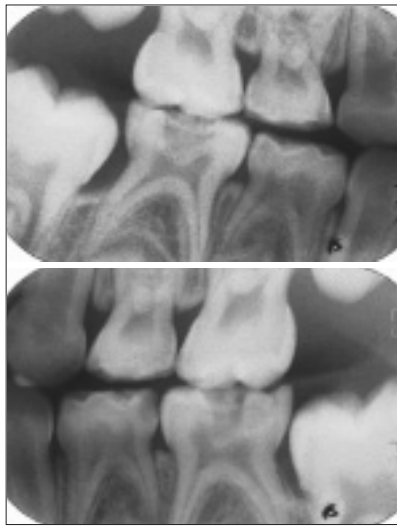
Preoperative bitewing radiographs showing dental caries with pulpal encroachment in the mandibular primary molars and proximal caries in the maxillary primary molars.
